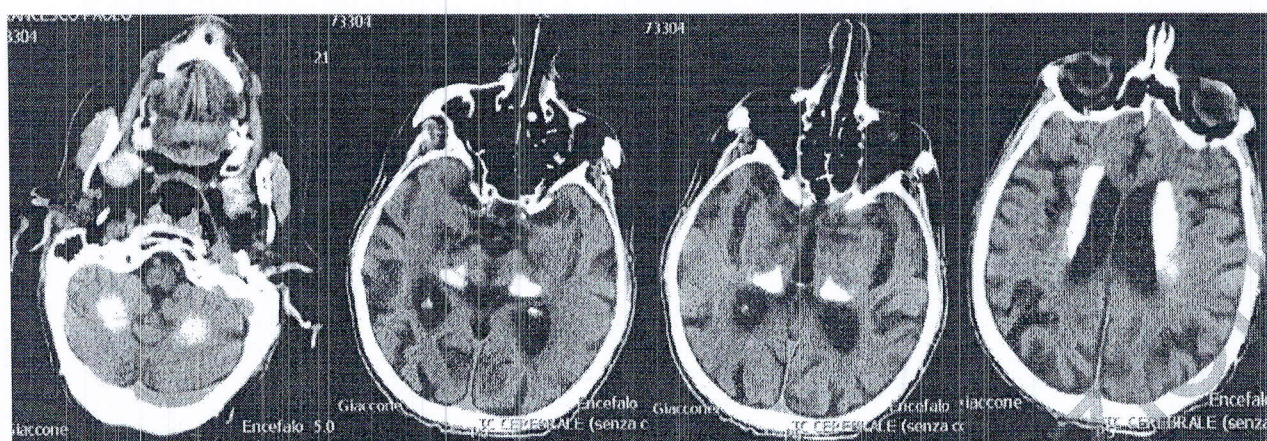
CT scan of brain showing bilateral cerebellar and basal ganglia calcification.
